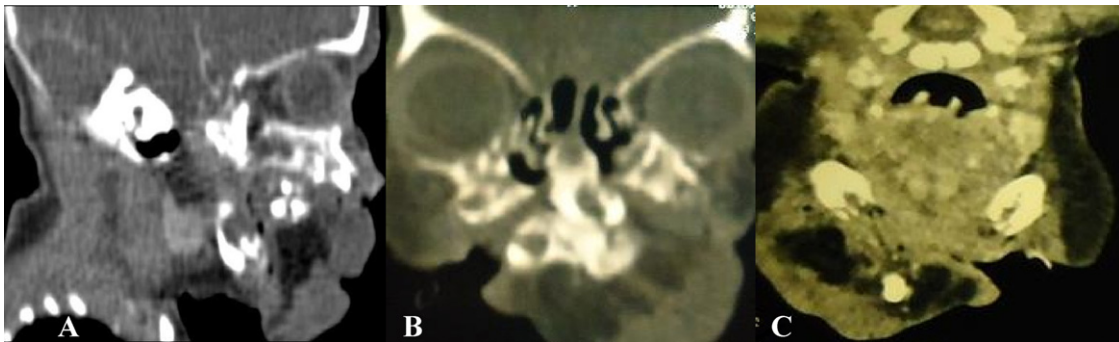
CT showed a complex mass protruding from the oral cavity. (A) Sagittal and (B), coronal and (C) axial views.
